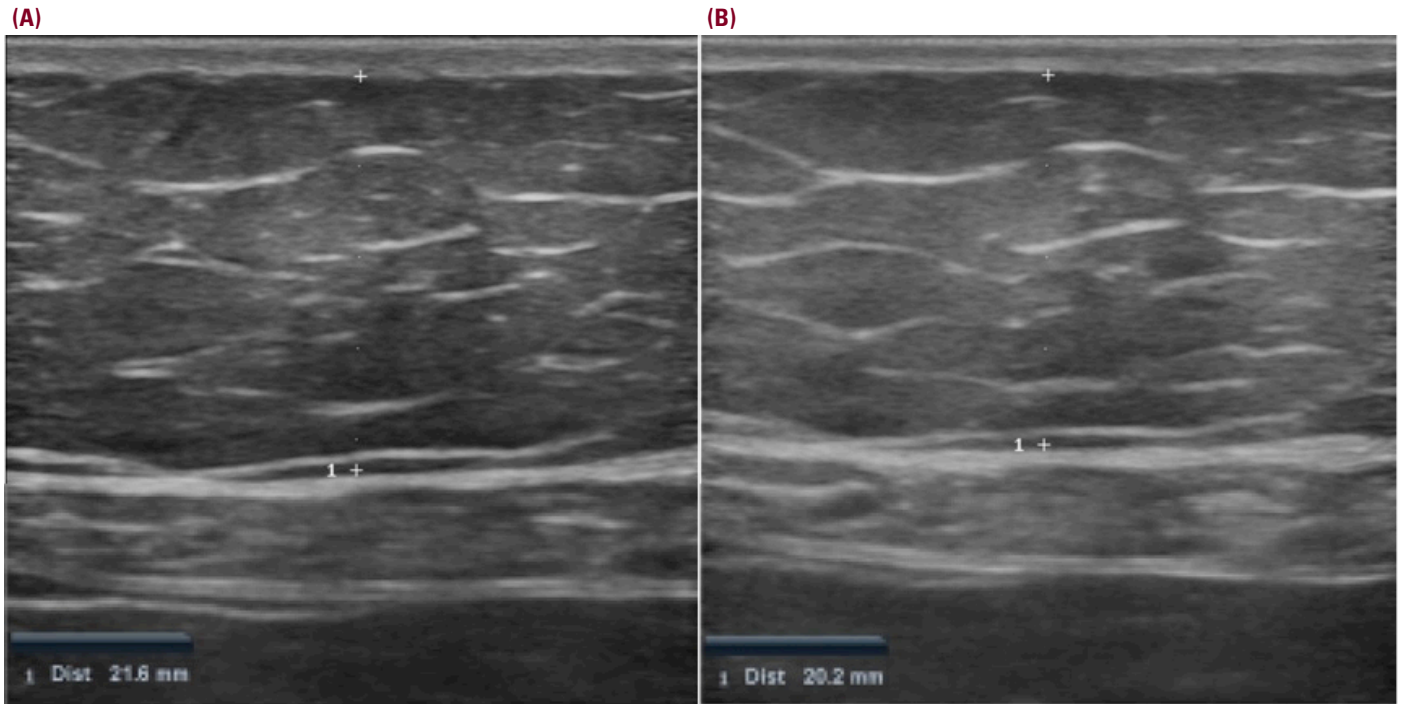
Ultrasound Abdominal Fat Thickness Measurement in Patient Treated with Vanquish™: (A) Before treatments; (B) 1-month post final treatment.TABLE 3.
